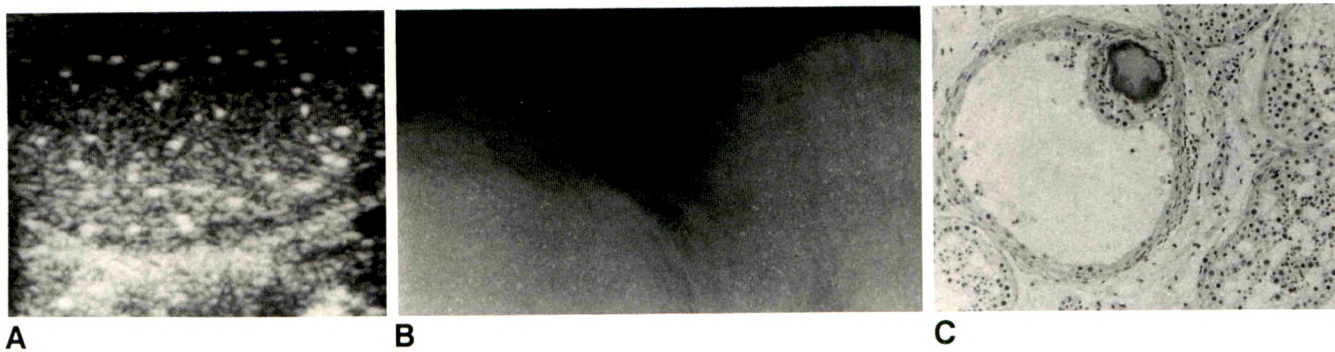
A, Longitudinal sonogram of right testicle shows multiple hyperechogenic foci caused by microlithiasis.
